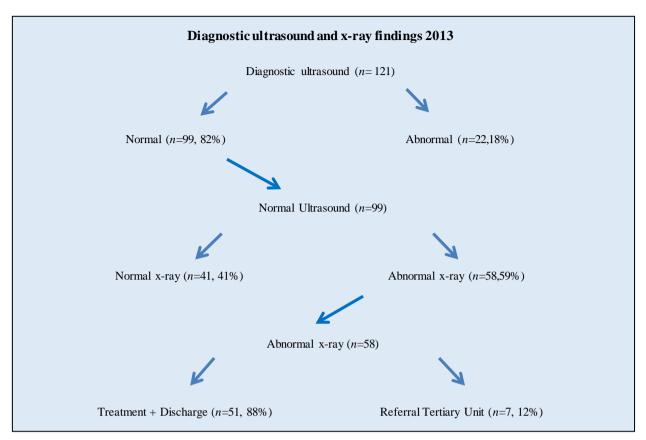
Diagnostic ultrasound and x-ray findings 2013
